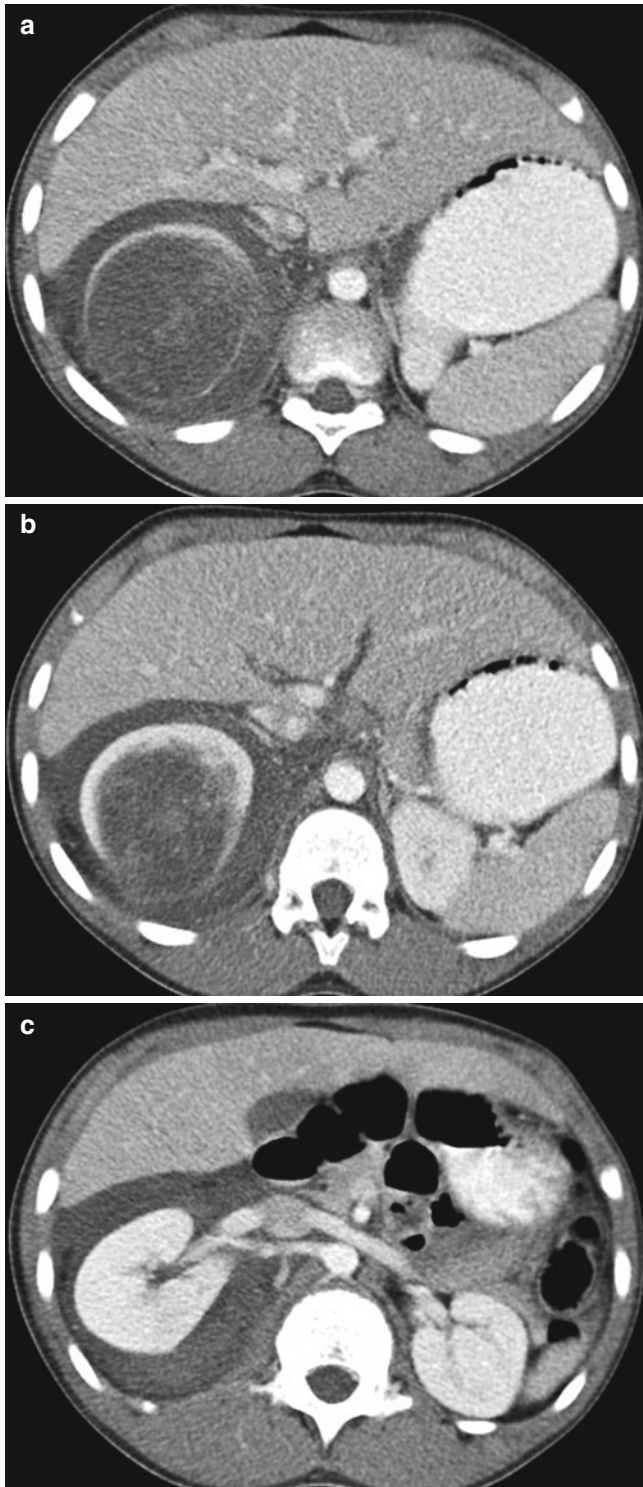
Renal cell carcinoma in a 13-year-old boy. (a and b) Contrast-enhanced CT scans show a poorly enhancing mass arising from the right kidney. Note also the perirenal hematoma. (c) Contrast-enhanced CT scan shows the perirenal hematoma surrounding the right kidney
